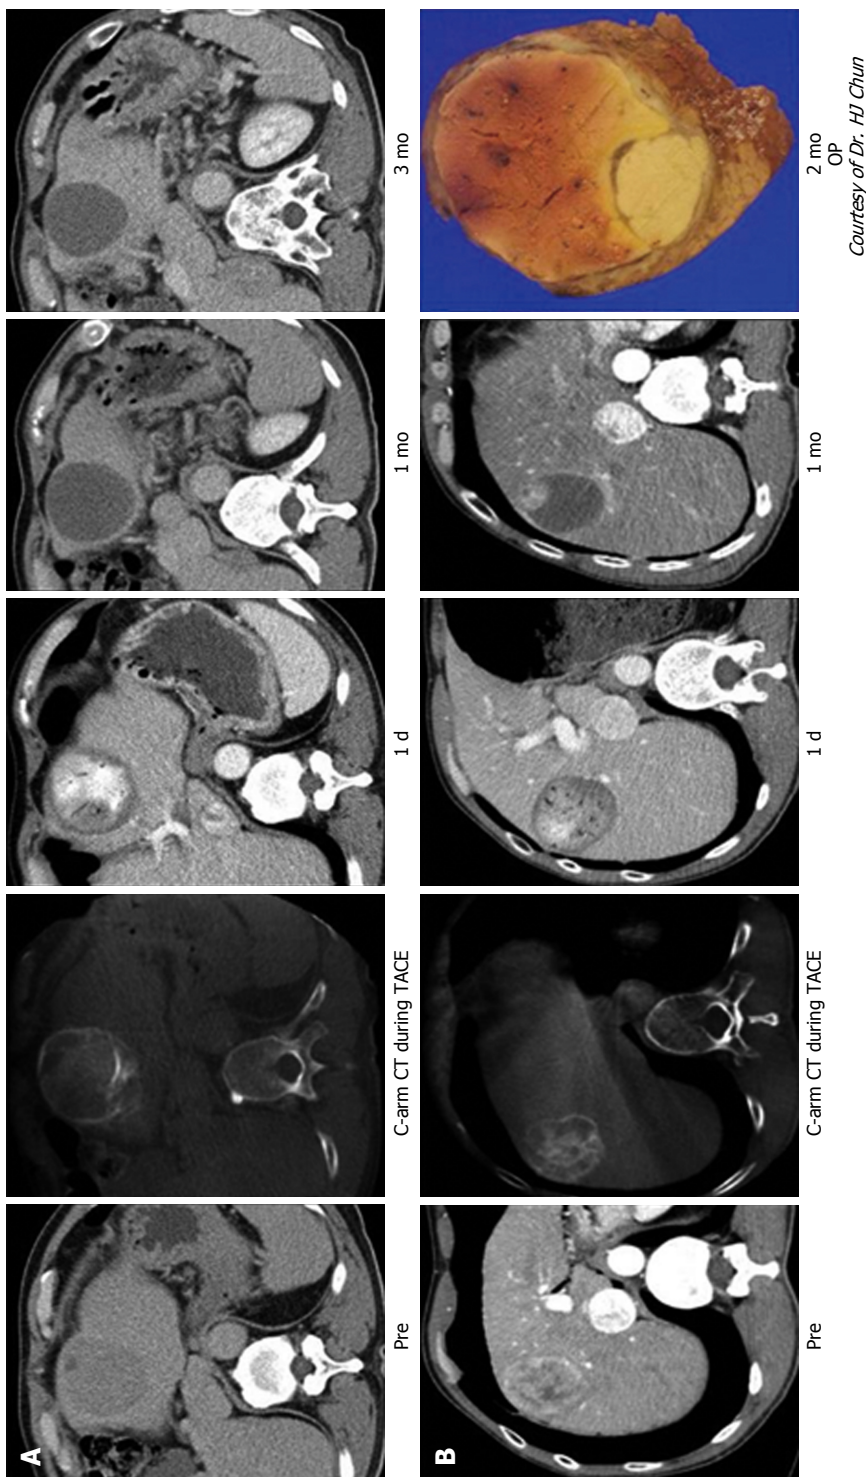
Typical imaging finding after transarterial chemoembolization with drug-eluting bead. A: Nodular hepatocellular carcinoma (HCC) with arterial enhancement showed the total necrosis of HCC through follow-up computed tomography (CT) imaging; B: Nodular HCC showed nodular arterial enhancing viable portion within the partial necrosis of HCC in follow-up CT imaging. After operation, viable HCC in resected HCC showed the matched lesion in the CT imaging.
